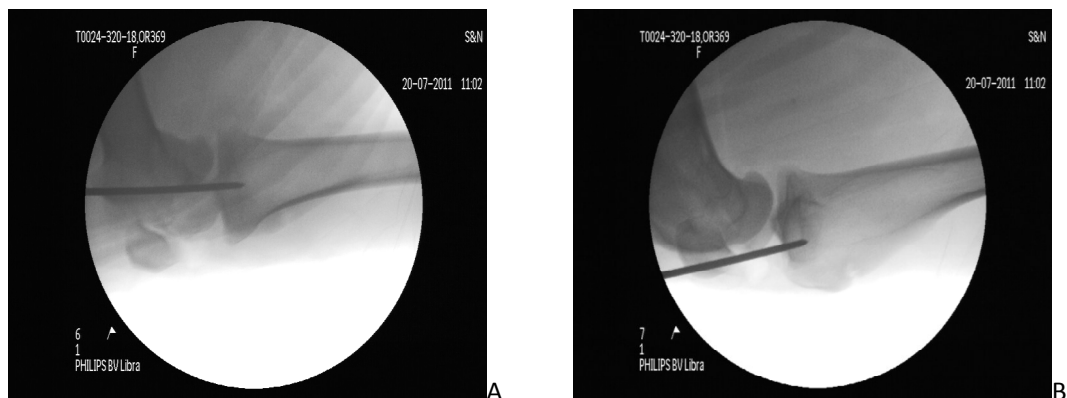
X-ray fluoroscopic images acquired from the left tibia highlighting the 3.2mm, Tip threaded guide wire inserted into the proximal tibia (A) A/P view, (B) M/L view
